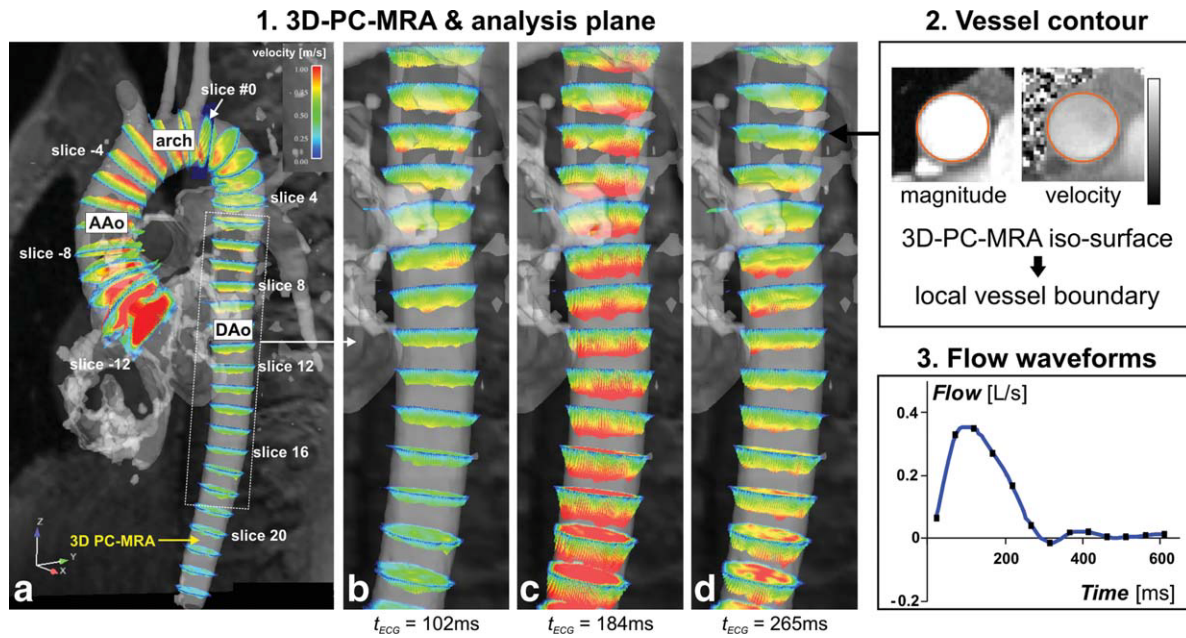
a: Visualization of pulse wave propagation within the thoracic aorta, based on flow-sensitive 4D MRI data. Equidistant analysis planes with an interanalysis plane gap of 10 mm were positioned upstream (negative analysis plane numbers) and downstream (positive analysis plane numbers) along the thoracic aorta, starting with analysis plane #0 (outlet of the left subclavian artery). b–d: Spatially varying flow profiles from the proximal to the distal DAo in analysis planes can be appreciated in successive systolic time frames: during early systole (b), profiles in the proximal DAo are already fully developed, while velocities are continuously lower further downstream. During peak systole (c), flow profiles reach their maxima in the entire DAo, while during late systole (d), flow profiles in the proximal DAo are already reduced compared to flow further downstream. 2. The boundaries of the derived 3D PC MR-angiography (PC-MRA) were used to automatically define the local vessel boundaries and lumen area. 3. Resulting flow waveform. AAo: ascending aorta, DAo: descending aorta.
